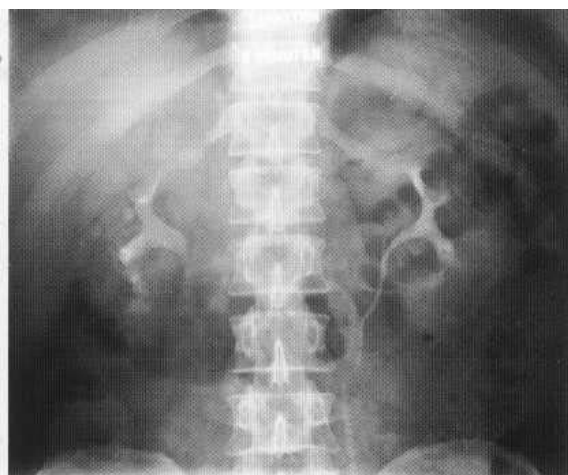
Dromedary hump related to the lateral border of the left kidney on IVU (A) and ultrasound (B).
